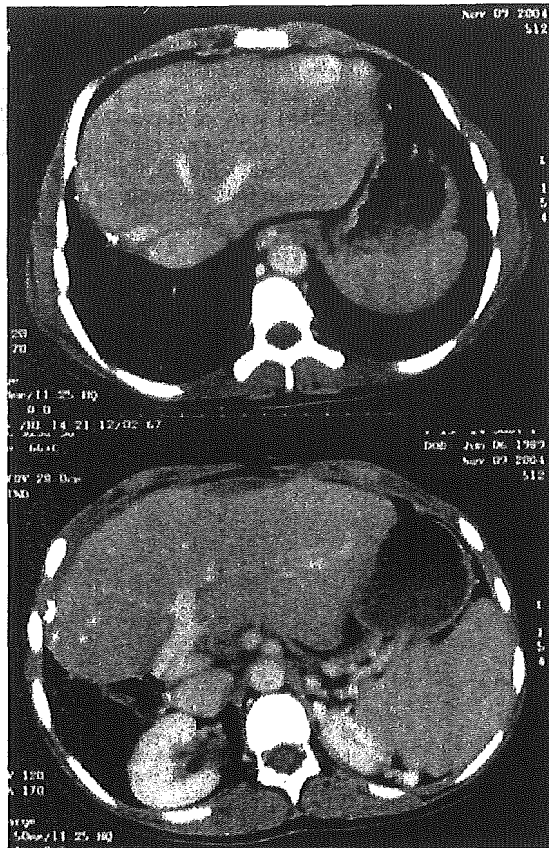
Follow-up computed tomography imagings performed 1 year after LT. The subcapsular hematoma has decreased in size with attenuation over time, and it is seen to be completely resolved.
